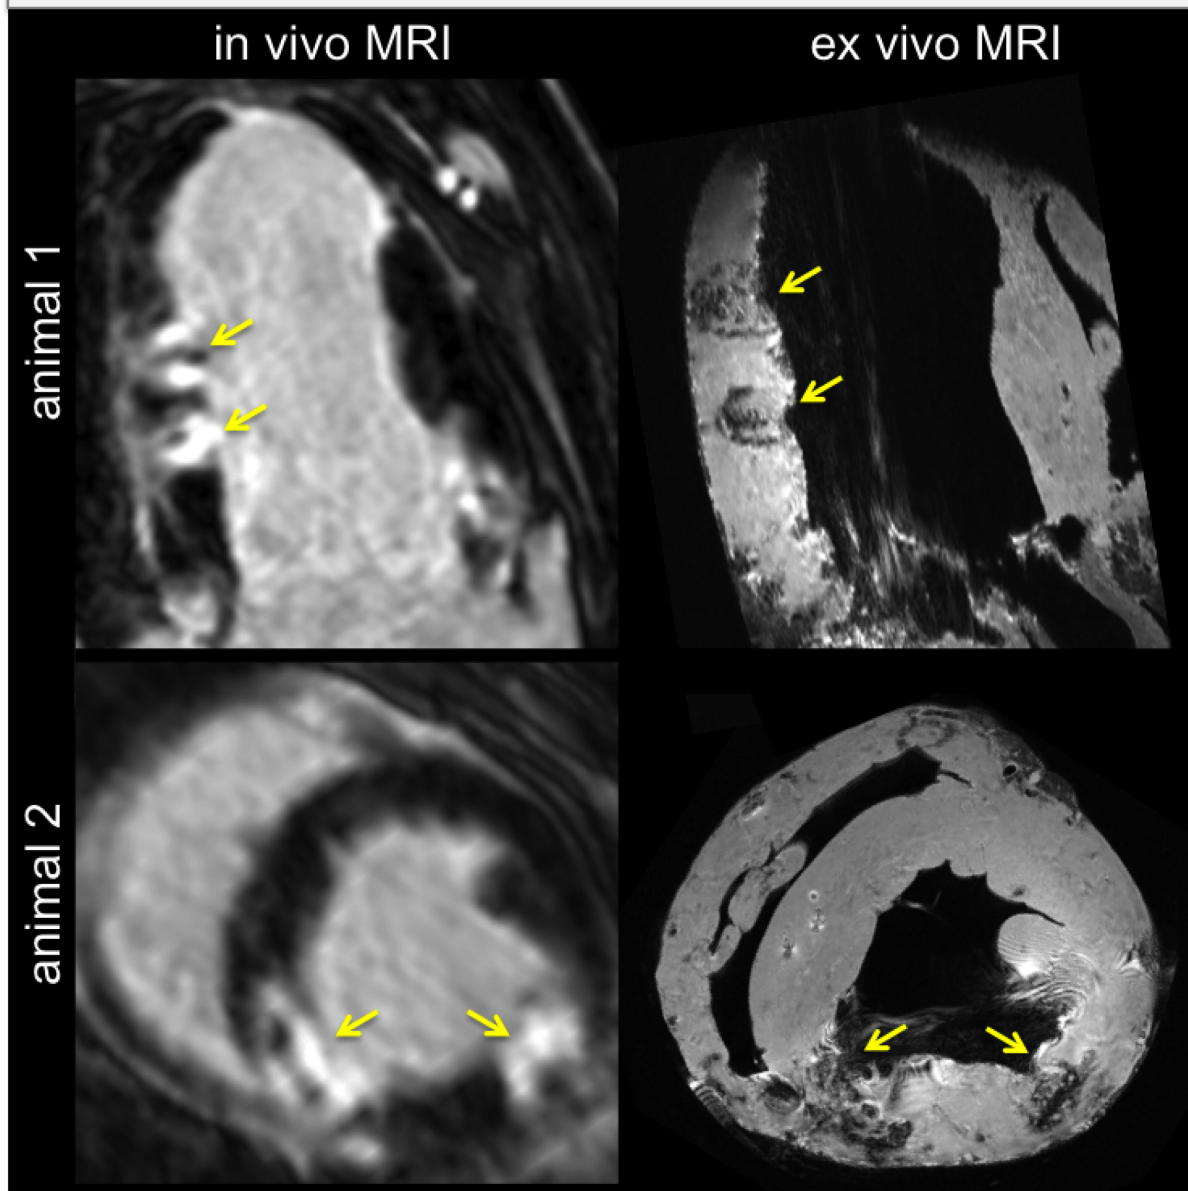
Different examples of needle RF lesions using ex vivo MRI.
